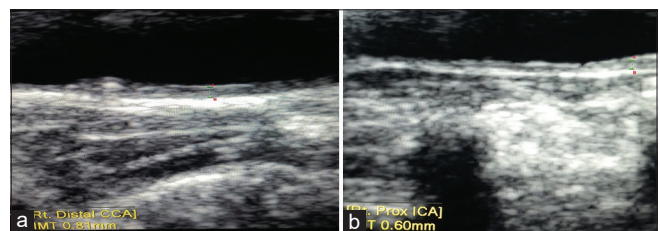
(a) Longitudinal scan of the common carotid artery on B-mode ultrasound. The measurement was taken as the distance between point A—the leading edge of the first echogenic line of the wall of the carotid artery (lumen–intima interface)—and point B—the leading edge of the second echogenic line (media–adventitia interface). (b) Longitudinal scan of the internal carotid artery on B-mode ultrasound. The measurement was taken as the distance between point A—taken at the lumen–intima interface—and point B—taken at the media–adventitia interface.
